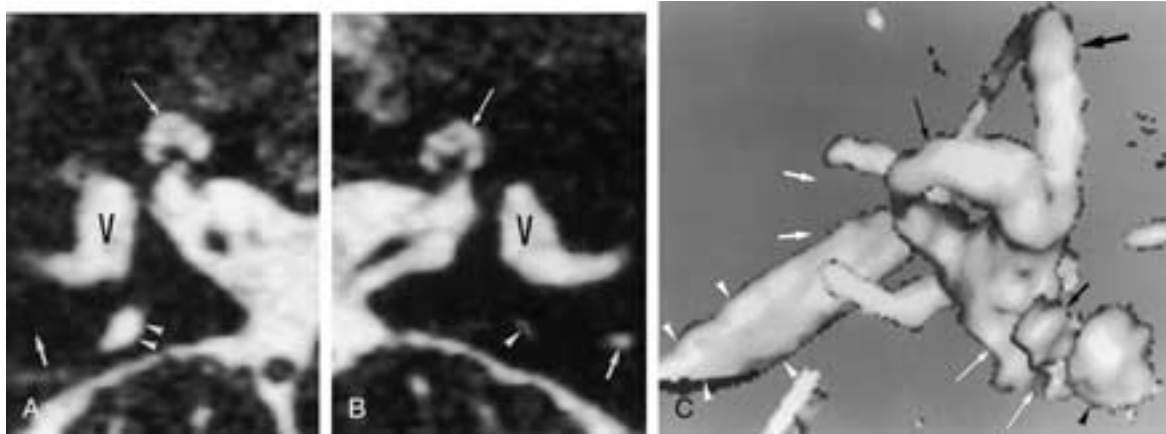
Partial absence of the posterior semicircular canal. A, Axial T2-weighted gradient-echo image through the right inner ear. A normal vestibule (*V*) can be seen. The cochlea is too small; the apical and second turns (*long white arrow*) are developed but are too small. A large endolymphatic duct/sac can be recognized (*white arrowheads*). The posterior semicircular duct cannot be seen; there is no high signal intensity at the site where the duct should be (*small white arrow*). B, Axial T2-weighted gradient-echo image through the left inner ear. Hypoplasia of the apical and second turns of the cochlea can again be appreciated (*long white arrow*). High signal intensity fluid can be seen in the posterior semicircular duct on the left side (*small white arrow*), and the endolymphatic duct has a normal size (*white arrowhead*). Normal vestibule (*V*). C, Three-dimensional virtual image of the right membranous labyrinth, made by using 0.7 mm thick T2-weighted gradient-echo images. The interruption of the posterior semicircular duct can be recognized (*small white arrows*). The large endolymphatic duct/sac can be seen (*white arrowheads*). The apical turn (*black arrowhead*) and the second turn of the cochlea (*small black arrow*) are slightly hypoplastic, but the basal turn (*long white arrows*) is severely hypoplastic (compare this with the normal cochlea in Figs. 21-15C, D and 21-17B, and especially with the same view in Fig. 21-51F). Normal lateral (*long black arrow*) and superior (*large black arrow*) semicircular ducts. The middle part of the posterior semicircular canal also cannot be seen on CT (not shown). This excludes fibrous obliteration of this segment of the canal. Labyrinthitis ossificans involving the posterior semicircular canal cannot be excluded. However, the association with several other congenital malformations, the absence of other obliterations or calcifications of the membranous labyrinth, and the normal aeration of the adjacent middle ear and mastoid all support the diagnosis of congenital absence of the middle part of the posterior semicircular duct.
